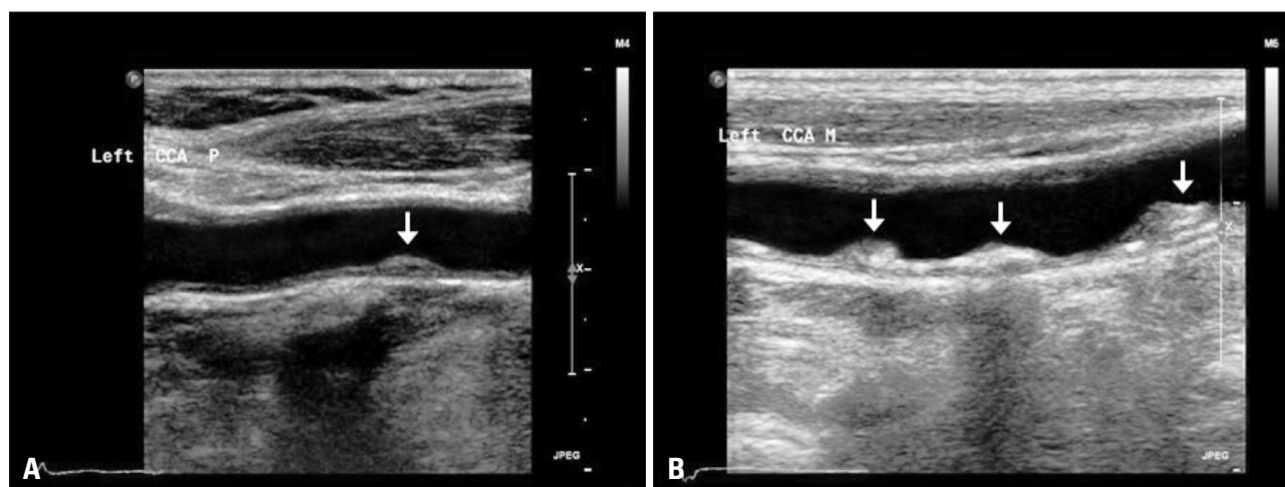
Carotid ultrasound showed carotid plaques in two patients, one patient has an asymptomatic single plaque with low cardiovascular risk (A), and the other patient has multiple complex plaques with recent stroke (B). The image (A) shows a small amount of smooth homogenous plaque (arrow) located on the far wall of the proximal CCA. In contrast, the image (B) demonstrates moderate to large amount of heterogeneous multiple plaques (arrows) with focal calcification and irregular surface, in mid CCA. CCA: common carotid artery.
